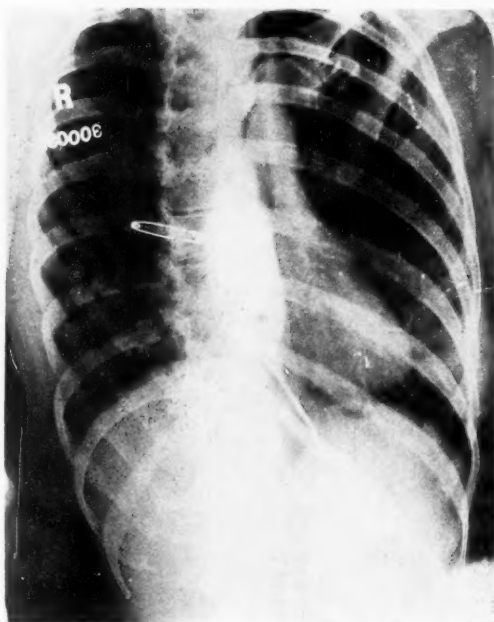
(Case 350,031.) Carcinoma at the cardia, with a history of dysphagia of two years' duration. The roentgenogram is suggestive of cardiospasm.
